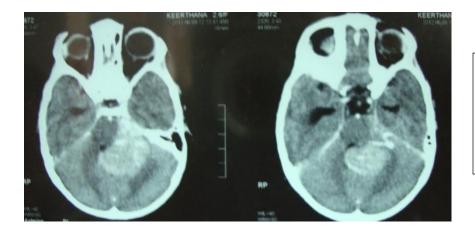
CT BRAIN SHOWING ENHANCING LESION IN THE MIDLINE WITH EXTENSION INTO LEFT SIDE DISPLACING FOURTH VENTRICLE TO OPPOSITE
